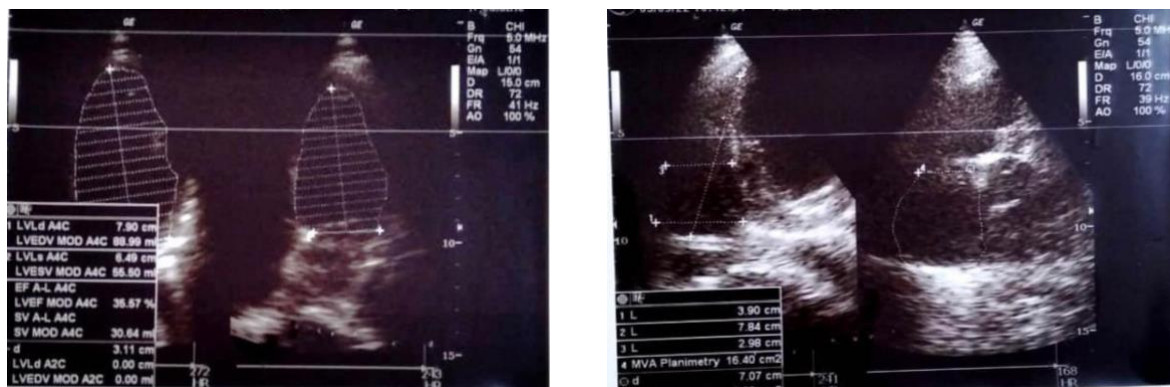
PPCM echocardiography
